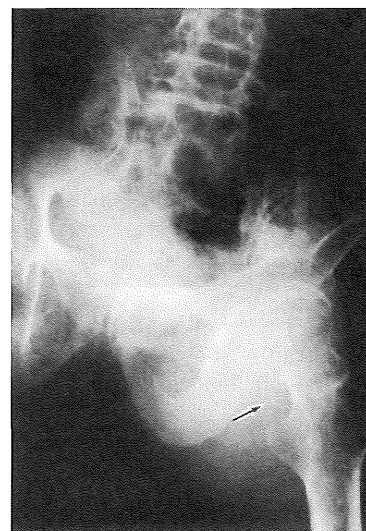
Roentgenography of the lower limb showing some calcification in the soft tissue of the inguinal portion (arrow).
